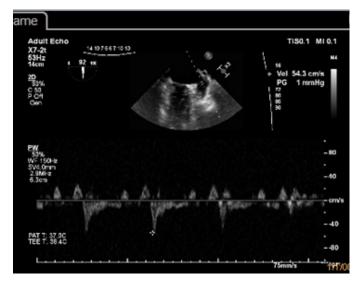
Transesophageal echocardiography. Midesophageal view at 90 degrees. Pulsed Doppler flow during sinus rhythm shows an empting velocity of > 40cm/s.
